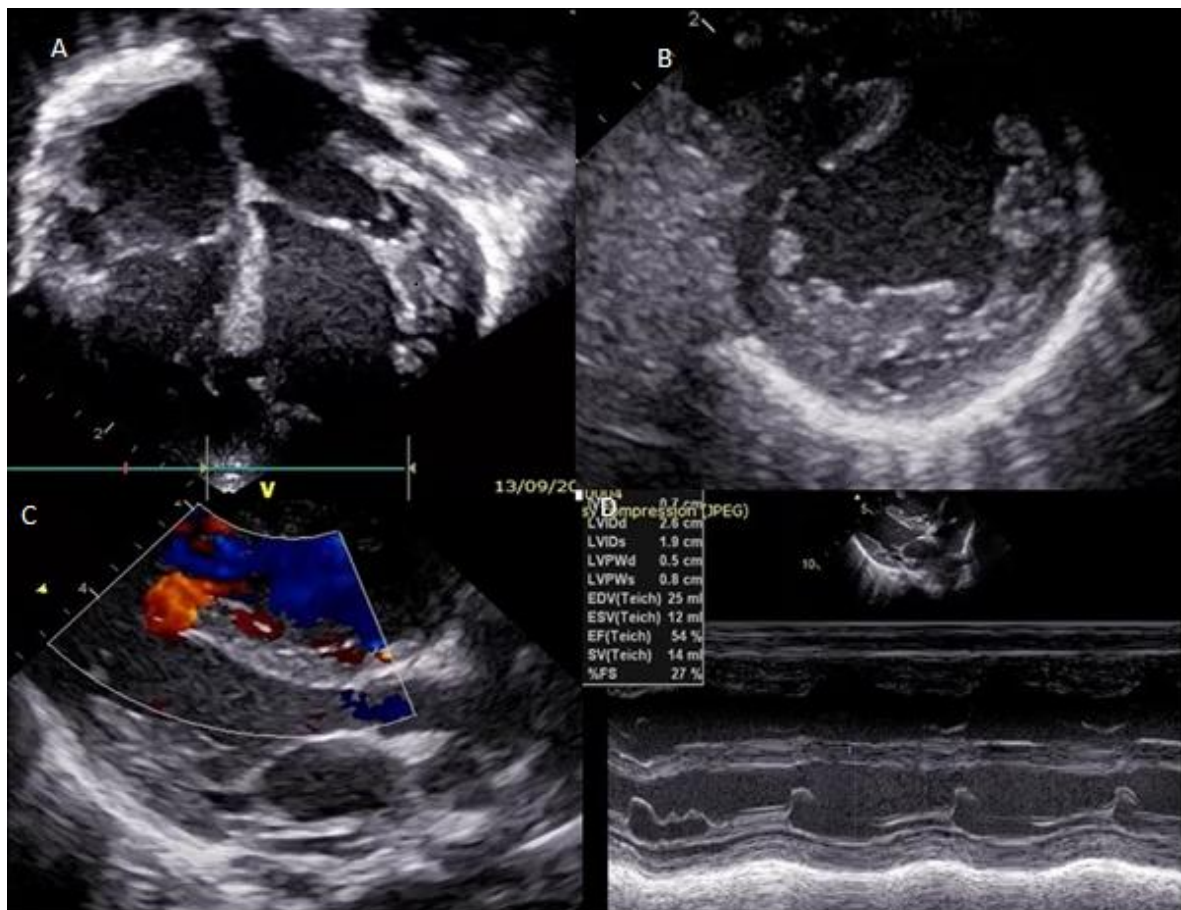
Echocardiography: (A) four-chamber view; showed dilated left side, non-compacted LV myocardium, and mid muscular VSD. (B) Short-axis view; showed the non-compacted to a compacted ratio of 2:1 (C) long-axis view; showed mid muscular VSD with, a left to right shunt. (D) M mode; show improvement of EF of 54% after treatment
